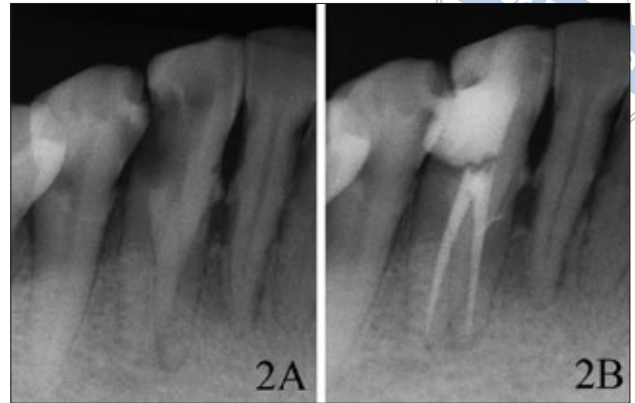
Case 2: (A) preoperative radiograph of tooth 43, indicating two roots; (B) final obturation of the root canals using vertical condensation of warm gutta-percha.
